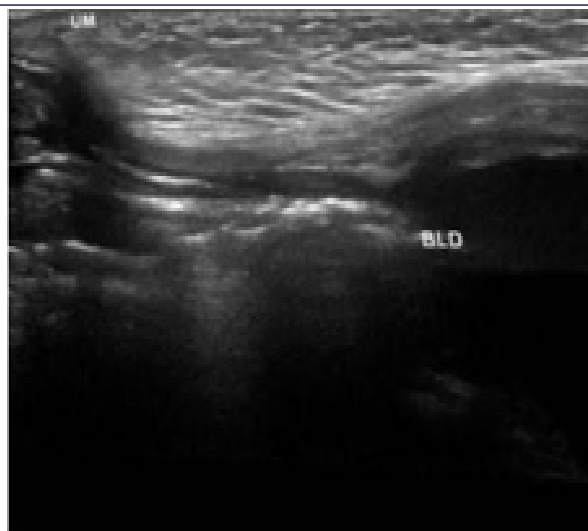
Patent VID was seen on ultrasonography abdomen
